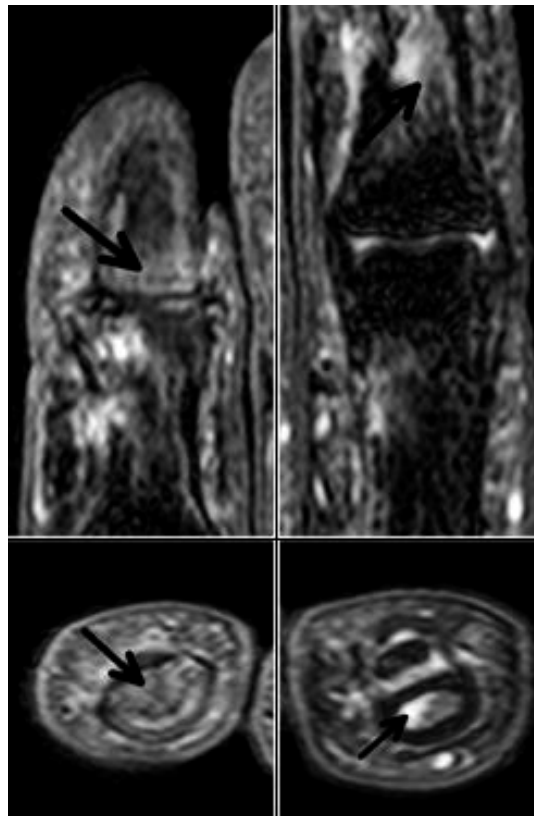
Magnetic Resonance Imaging: bone marrow lesions (arrow) were present in the second distal interphalangeal joint (A) and third proximal interphalangeal joint (B)
